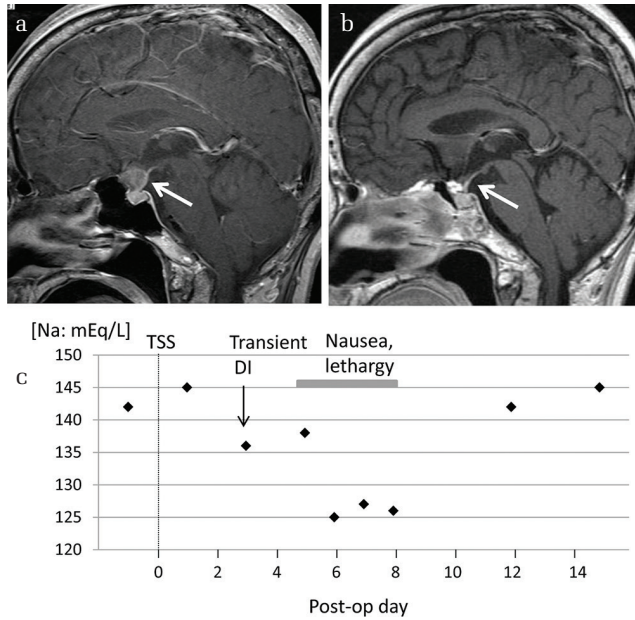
A 60-year-old woman with tuberculum sellae meningioma. (a) Preoperative magnetic resonance image (MRI) shows a suprasellar tumor, which slightly compressed the pituitary stalk (arrow). (b) Postoperative MRI shows total removal of the tumor and the intact pituitary stalk (arrow). (c) Peri-operative changes in the blood Na level, which hit the lowest point (125 mEq/L) 6 days after surgery. TSS: transsphenoidal surgery, DI: diabetes insipidus.
